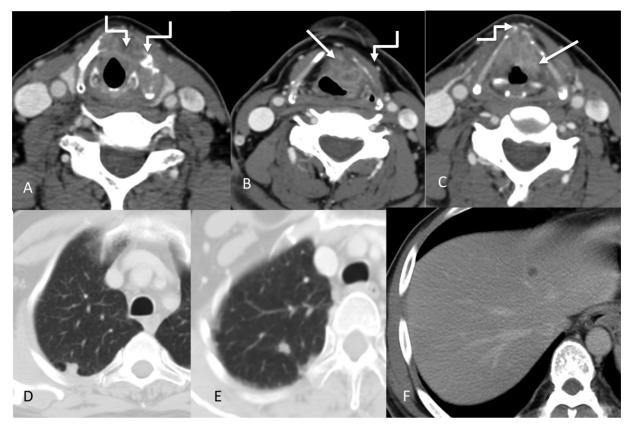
Transglottic laryngeal cancer. Axial CT images (A-C) showing the primary enhancing mass (straight arrows) involving the true vocal cords bilaterally and left false cord. There is gross involvement of the thyroid cartilage (more on the left side) with subtle extralaryngeal spread anteriorly (shouldered arrows). Right arytenoid cartilage appears sclerosed. The left para glottic space is also involved. In addition, lung nodules and liver lesions were also identified (D-F).
